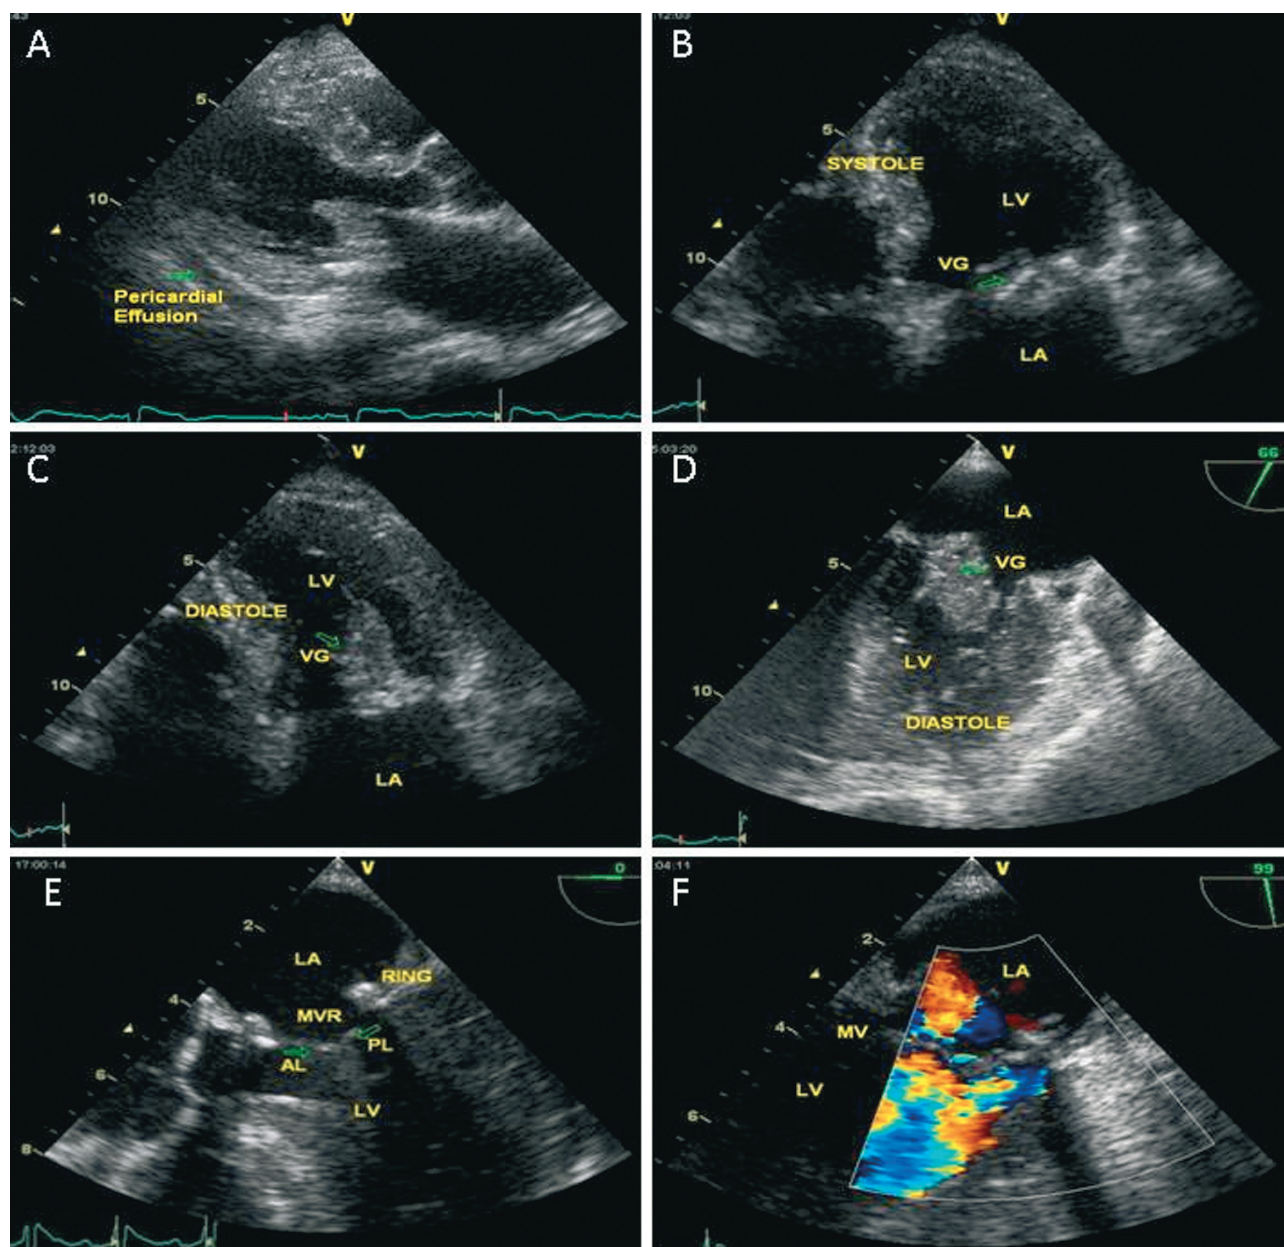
Echocardiographic findings. (A) Transthoracic echocardiography in parasternal long-axis view presented an image of pericardial effusion. (B-C) Transthoracic echocardiography apical 4-chamber images during systole and diastole showing a giant vegetation (VG) attached to the posterior mitral valve leaflet. (D) Transoesophageal echocardiography examination did not show perivalvular extension. (E-F) The postoperative transoesophageal echocardiography did not show any mitral regurgitation.
